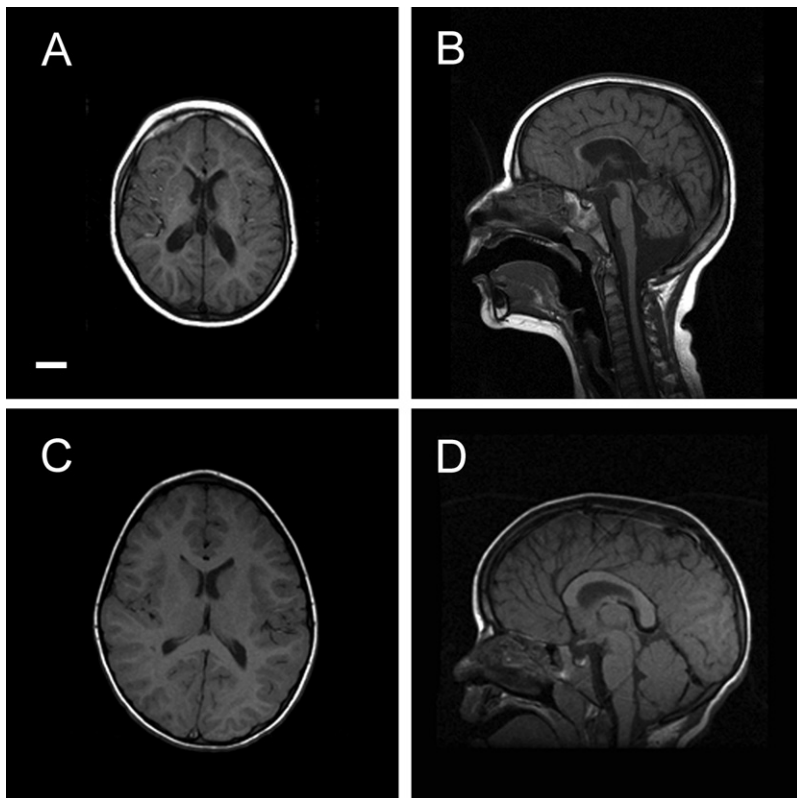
Brain MRI of a Patient with a *TRAPPC9* Mutation
